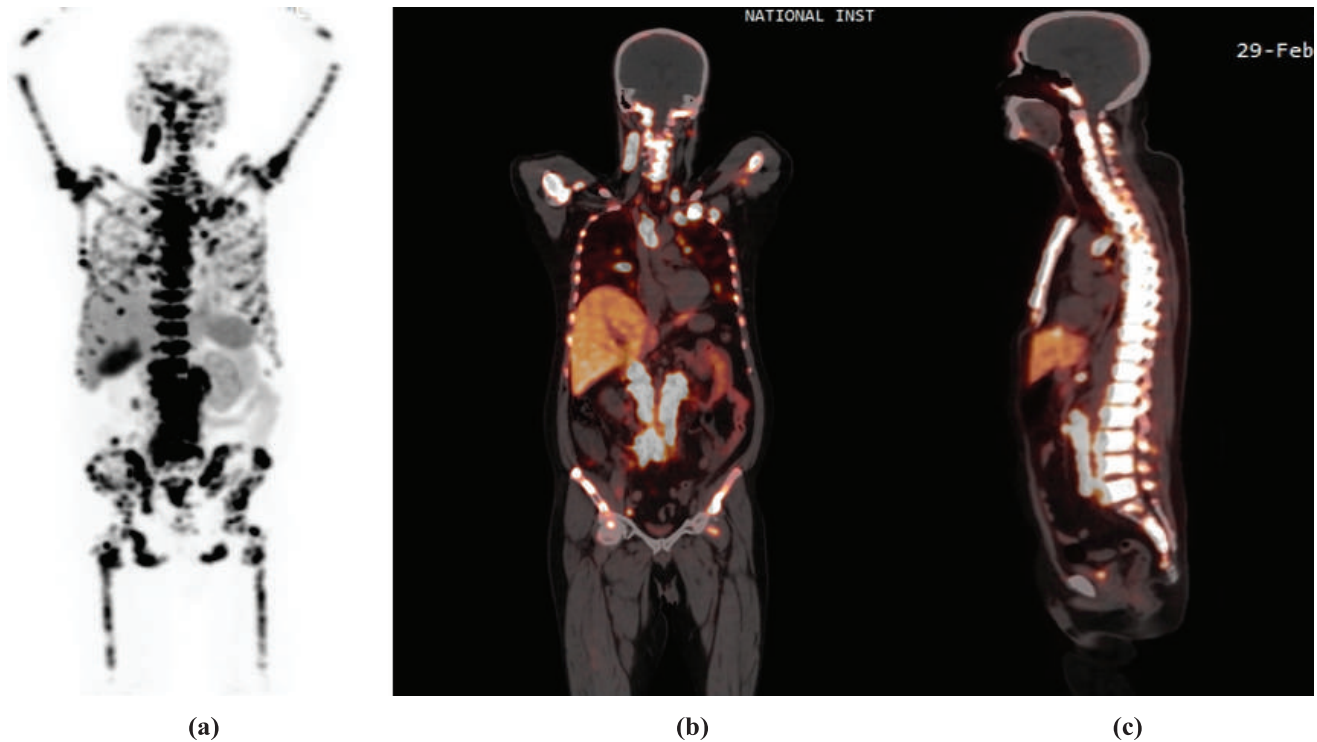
Maximum intensity projection (a), coronal (b) and sagittal (c) ^{18}F -PSMA-1007 PET-CT images show extensive nodal and skeletal metastases, revealing disease progression. The PSMA-avid lesions included all previously FDG-positive areas, with additional sites of metastases.
